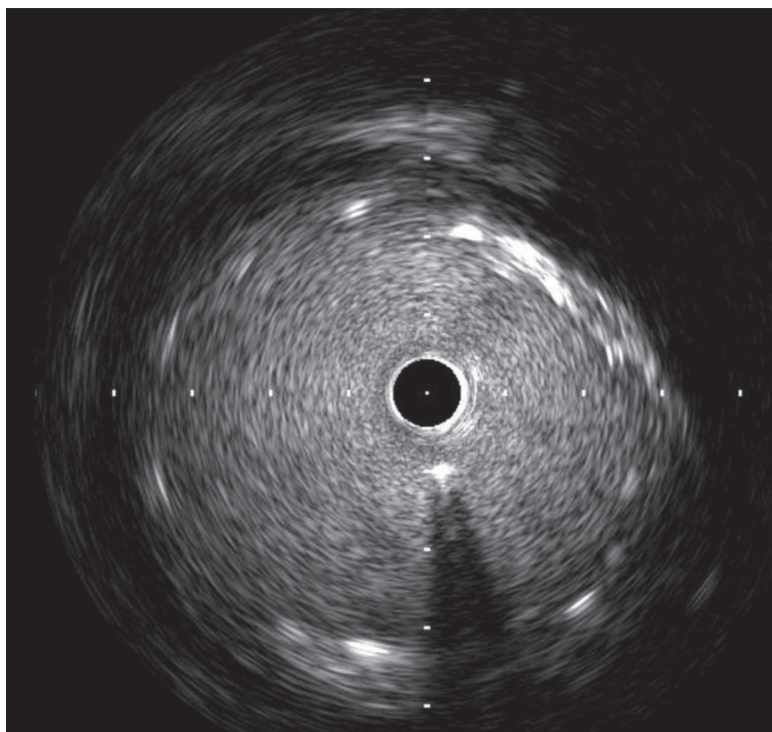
Intravascular ultrasound showed the proximal stent edge just landed on the distal edge of the aneurysm.
